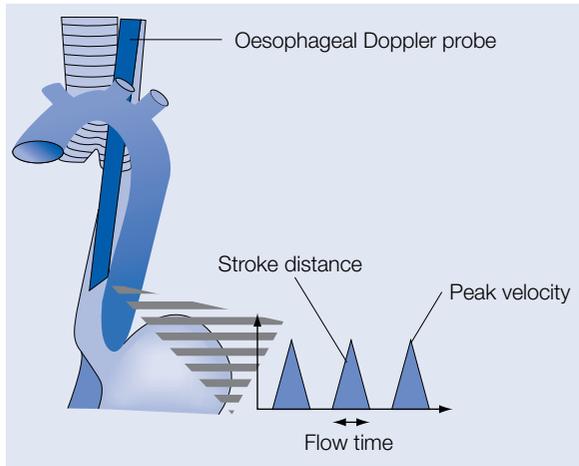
Oesophageal Doppler probe continuously measures velocity waveforms from the descending thoracic aorta. With a nomogram stroke distance (area under waveform) provides an estimate of stroke volume. Acceleration and peak velocity indicate myocardial performance, while flow time is related to circulating volume and peripheral resistance*
